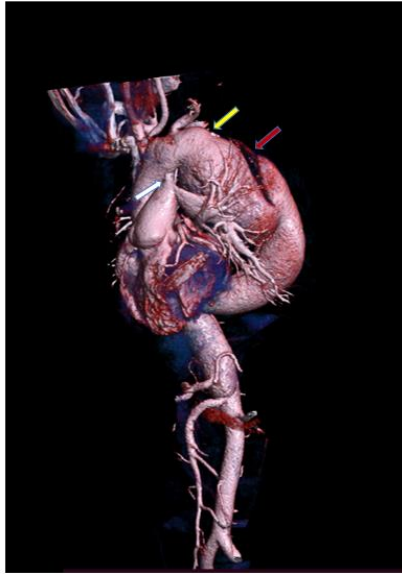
CTA 3D Image Anterior. White arrow: PDA device, yellow arrow: Aneurysmal portion of aortic arch and proximal descending aorta
